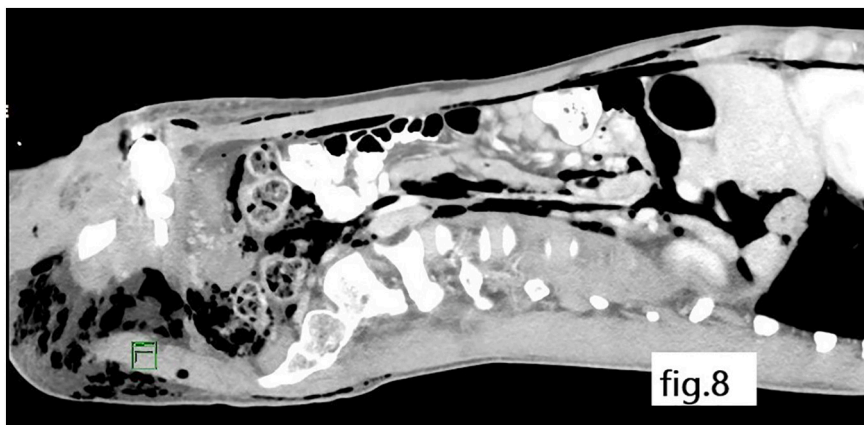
Saggital CT cut, showing gas in pelvis, peritoneum, retroperitoneum.
